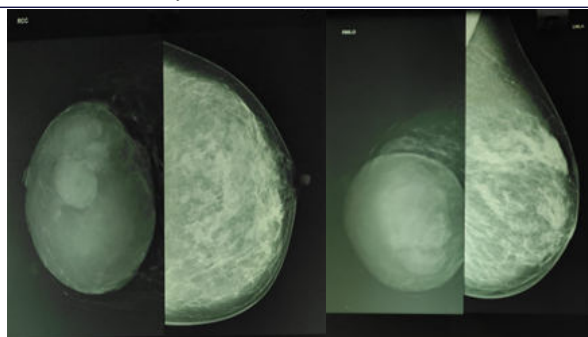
Xray mammogram – CC & MLO view of both breast showing right breast lump
